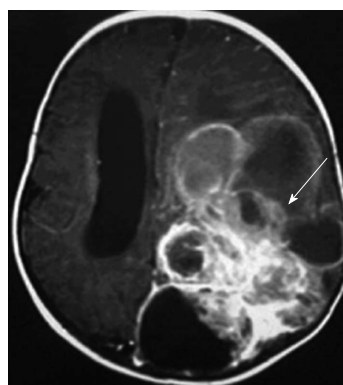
Case of anaplastic astrocytoma. Magnetic resonance imaging (T1 Fast Spin Echo, axial plane) 7 d after birth showing large parieto-occipital lesion with solid and cystic components (white arrow).
